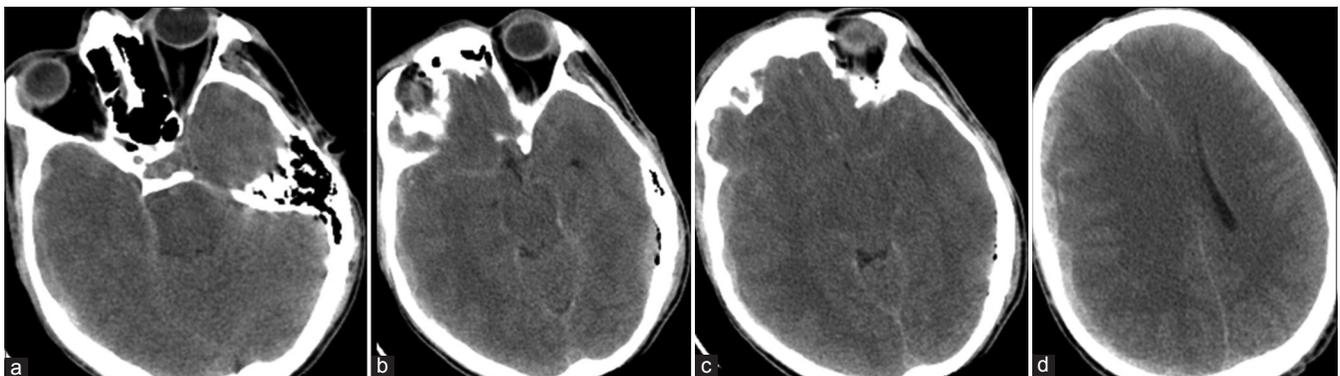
(a-d) Pre-operative axial plan cranial computed tomography was taken in the emergency service, showing early preoperative traumatic acute subdural hematoma diffuse edematous brain parenchyma and midline shift, no clear evidence of epidural hematoma on the left occipital region or on the left side of the posterior fossa
